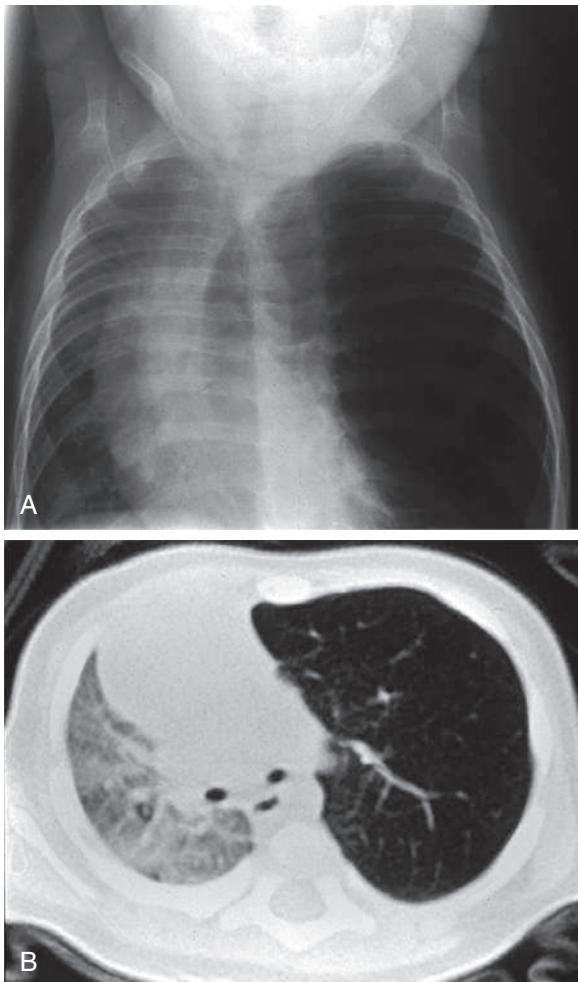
Chest x-ray (A) and CT scan (B) of a congenital large hyperlucent lobe (congenital lobar emphysema). (From Bush A, Abel R, Chitty L, et al. Congenital lung disease. In: Wilmott RW, Deterding RR, Li A, et al., eds. Kendig's Disorders of the Respiratory Tract in Children, 9th ed. Philadelphia: Elsevier; 2019: Fig. 18.32.)
